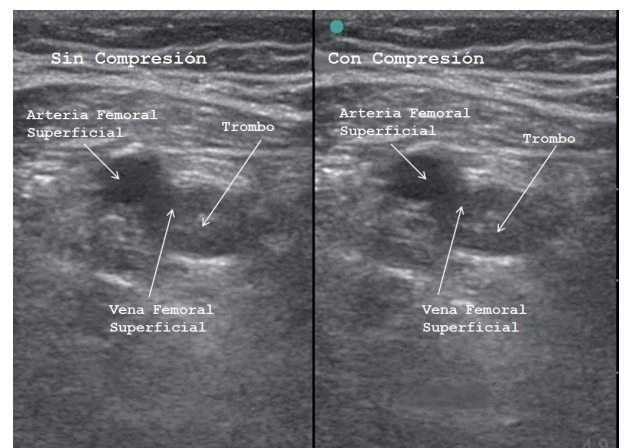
Ultrasound image of deep vein thrombosis. The femoral artery and vein can be seen with a thrombus (echogenic image inside the vein lumen), without (left) and with (right) compression, with no modification of the image.
